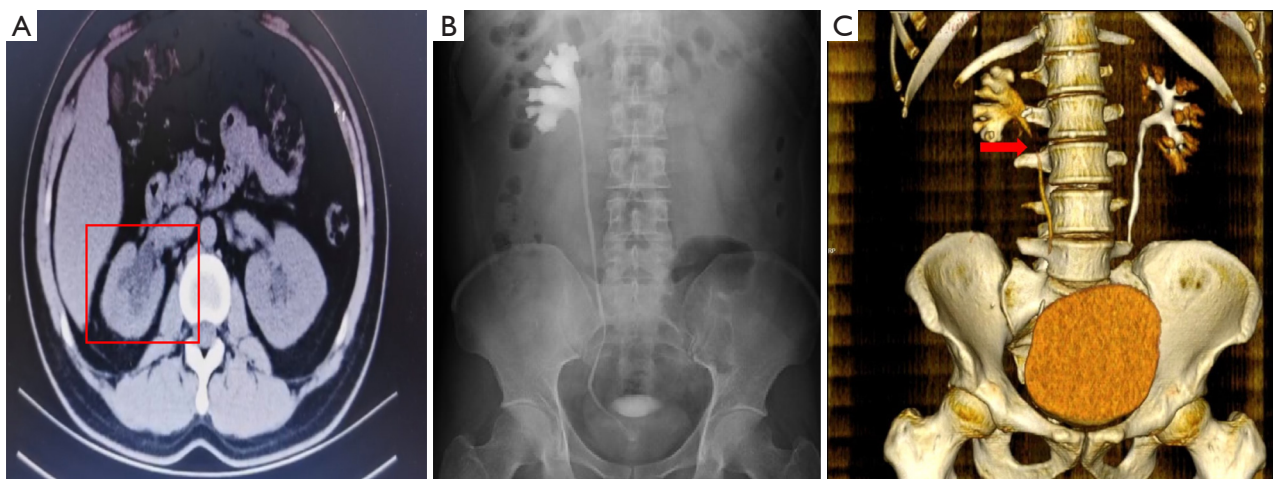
Images after surgery. (A) CTU showed significantly reduced right hydronephrosis. Red box indicates the hydronephrosis. (B) Right retrograde pyelography two months after surgery showed unobstructed spontaneous excretion. (C) CTU showed unobstructed spontaneous excretion in right ureter 5 months after surgery (arrow). CTU, computed tomography urography.
